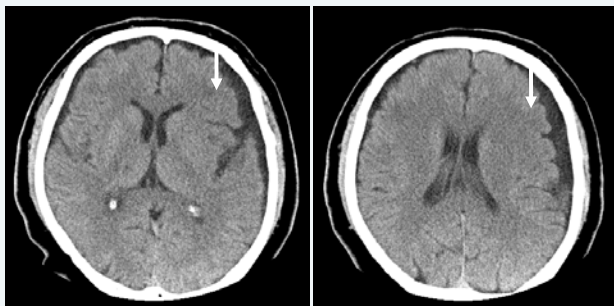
Emergency CT scan showing loss of corticomedullary differentiation in the left opercular cortex (arrow).
